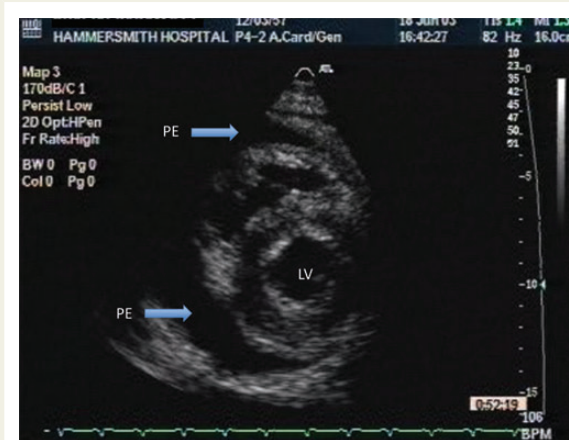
Parasternal short-axis view from a patient with moderate concentric pericardial effusion (arrows). LV, left ventricle; PE, pericardial effusion.
